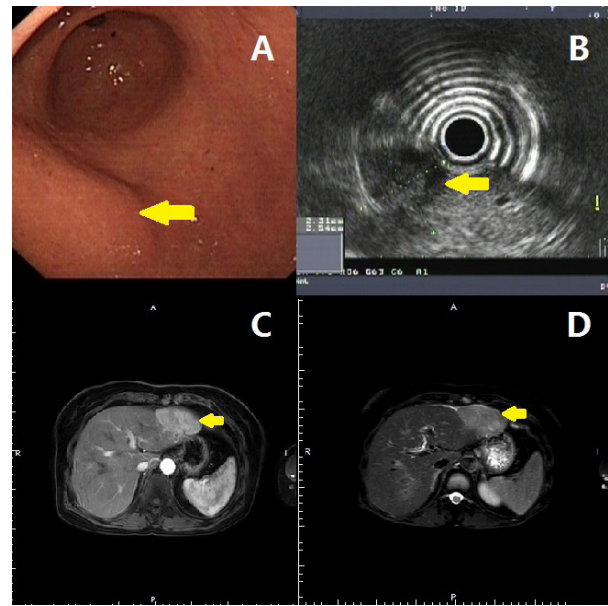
Diagnosis of the present case of PIHMM. Gastroscopy showed a flat bulge of about 2.5×2.3 cm with a smooth surface mucous membrane in the upper part of body of the stomach (yellow arrow) (A). The endoscopic ultrasonography (EUS) confirmed the above lesion as an external compression caused by the left lobe of the liver (yellow arrow) (B). The MRI revealed a 6.4×4.0 cm mass occupying the left-lateral hepatic lobe presenting an unclear boundary with the front edge of the stomach. The mass was showed as hypo-intensity on T1WI and peripheral serpiginous vessels were shown (yellow arrow) (C), while slightly hyper-intensity on T2WI signals (yellow arrow) (D).
